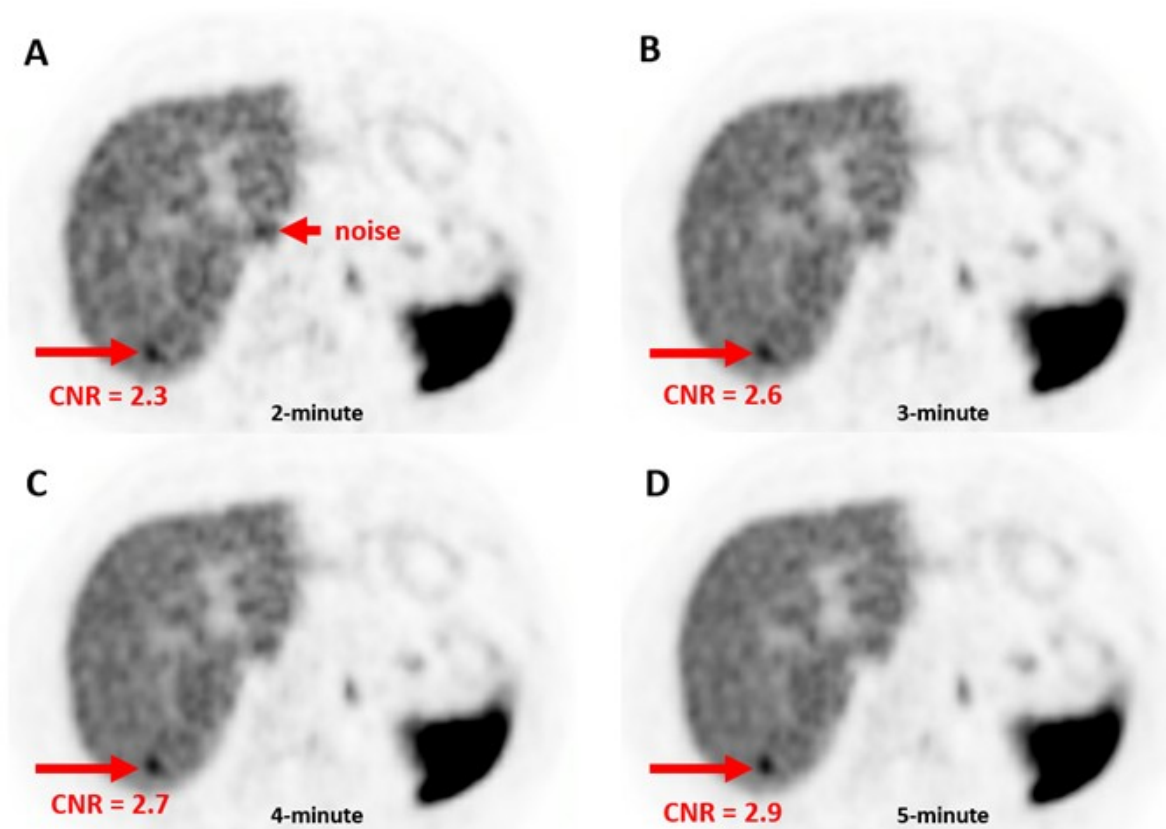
^{68}Ga DOTATATE PET transaxial slices with several different list mode reconstruction times. Red arrow (long arrow) shows lesion with baseline 5-minute CNR= 2.9. Background noise (short arrow) difficult to distinguish from true lesion. A) 2-minutes, CNR measured=2.3; B) 3-minutes, CNR measured= 2.6; D) 4-minutes, CNR measured=2.7; D) 5-minutes, CNR measured=2.9. Lesion SUV mean=9.9. All images are scaled with upper threshold SUV=15.
